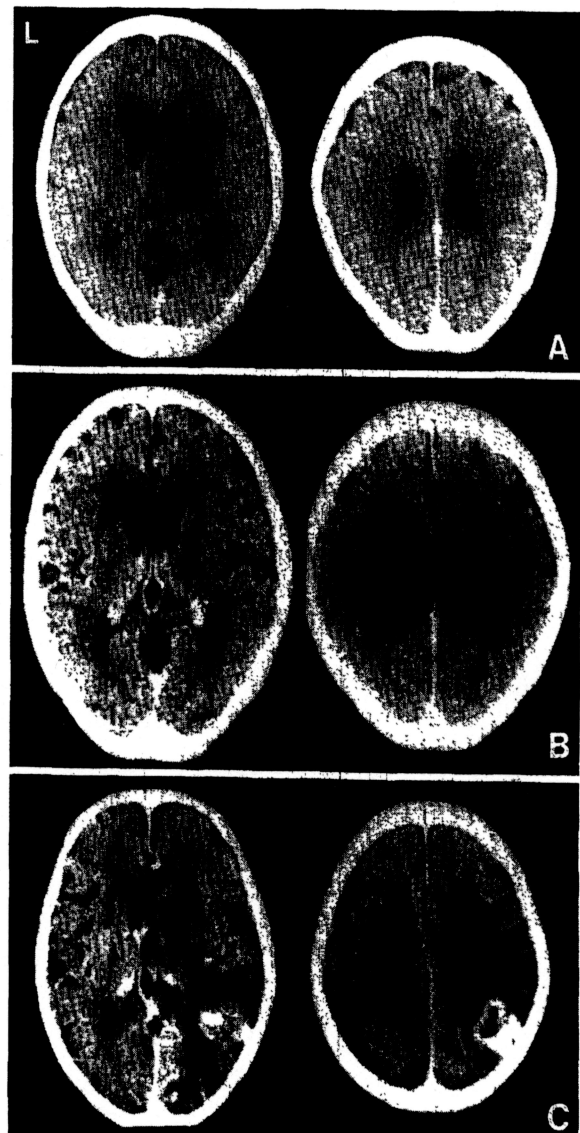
Sequential postcontrast CT scans in Case 3. A: On admission, a round low-density area without contrast enhancement in the right basal ganglia and thalamus is shown. B: One year prior to readmission, no recurrence of tumor is seen. C: At readmission, ring enhancement in the right parieto-occipital region and a diffuse low-density area in the white matter are seen.
